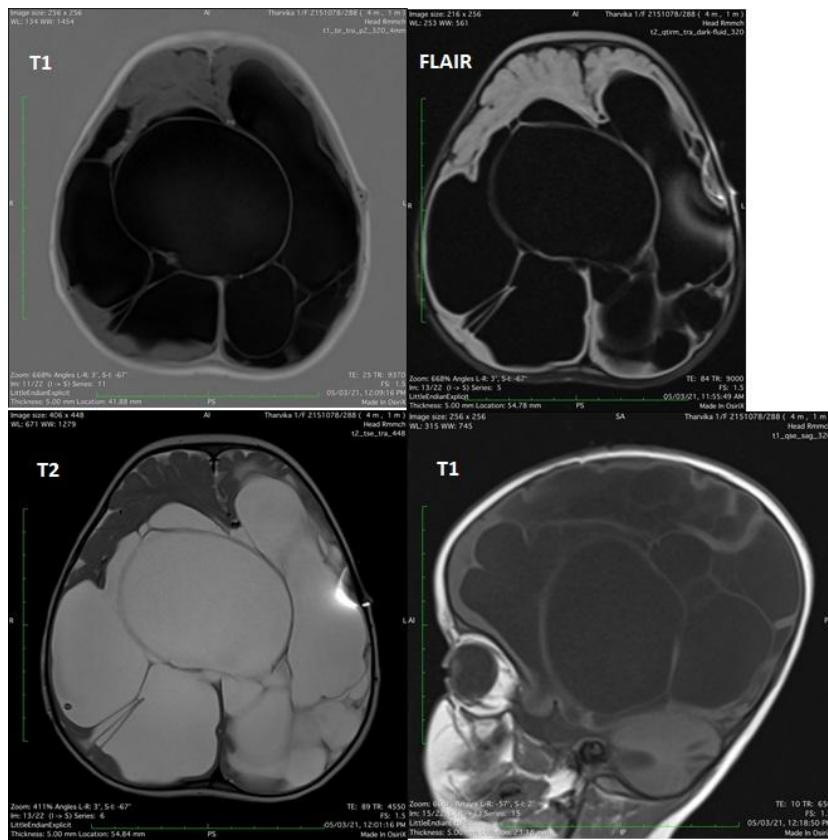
MRI depicting multiple cystic lesions replacing brain parenchyma – Porencephaly
